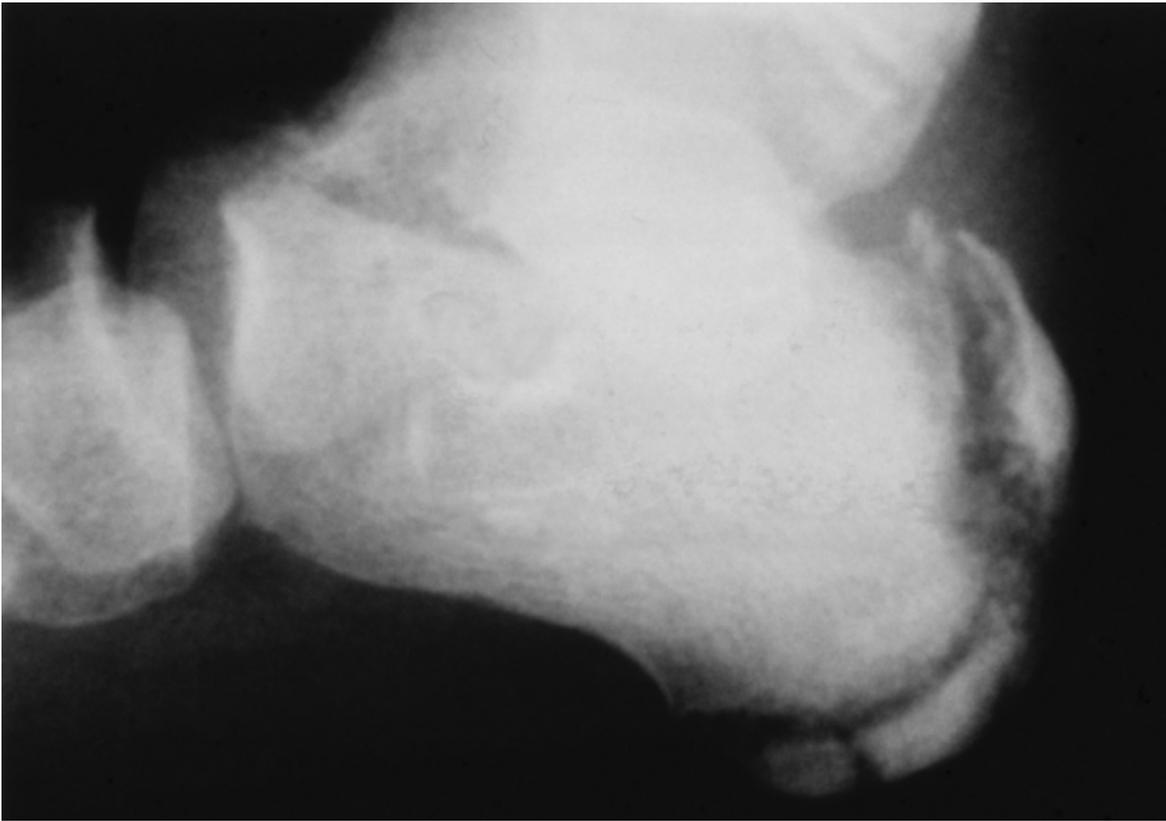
Figure 25C2-18 Lateral radiograph of the calcaneus. Note the irregularity, especially in the superior part of the apophysis. Fragmentation and increased density are common occurrences in the calcaneal apophysis.
